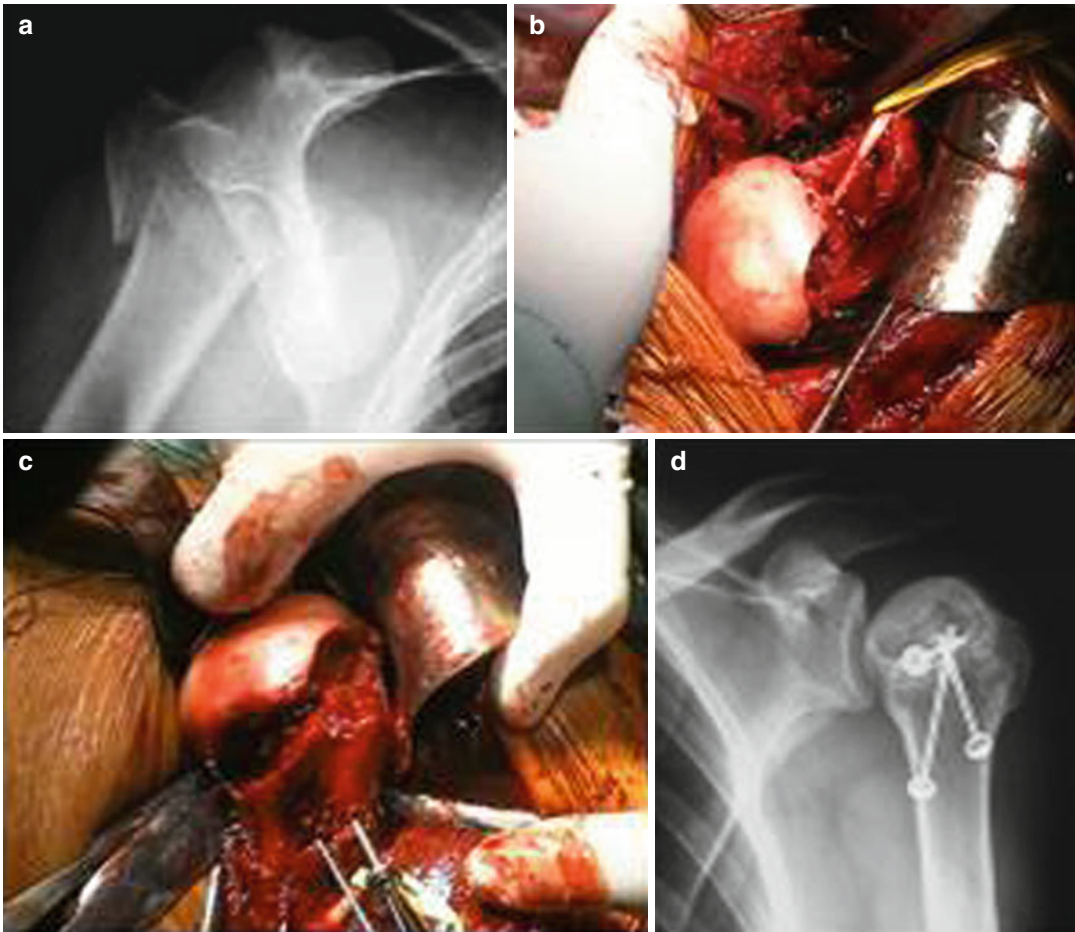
Complex four-part anterior fracture-dislocation (type VC of the revisited Neer classification). (a) Anteroposterior X-ray showing a four-part anterior dislocation fracture (type VC of the revisited Neer classification). (b) Image of the humeral head after being recovered from the subscapularis fossa; four-part
